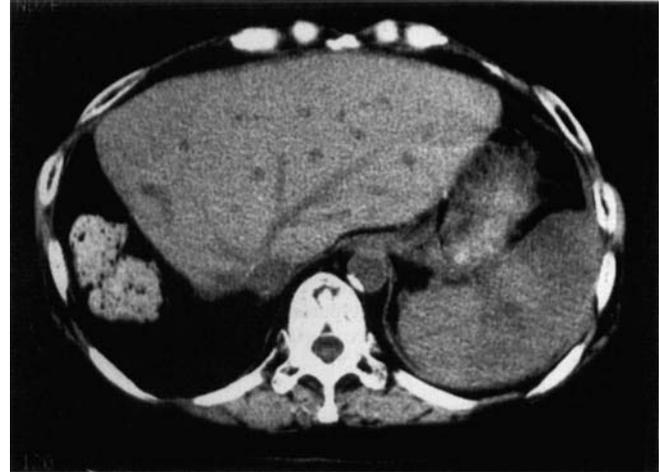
Plan CT scan of the grafted liver in the 6th month after the shunt ligation. Scan reveals recovery of the density of liver parenchyma, with a CT value of +20 HU
